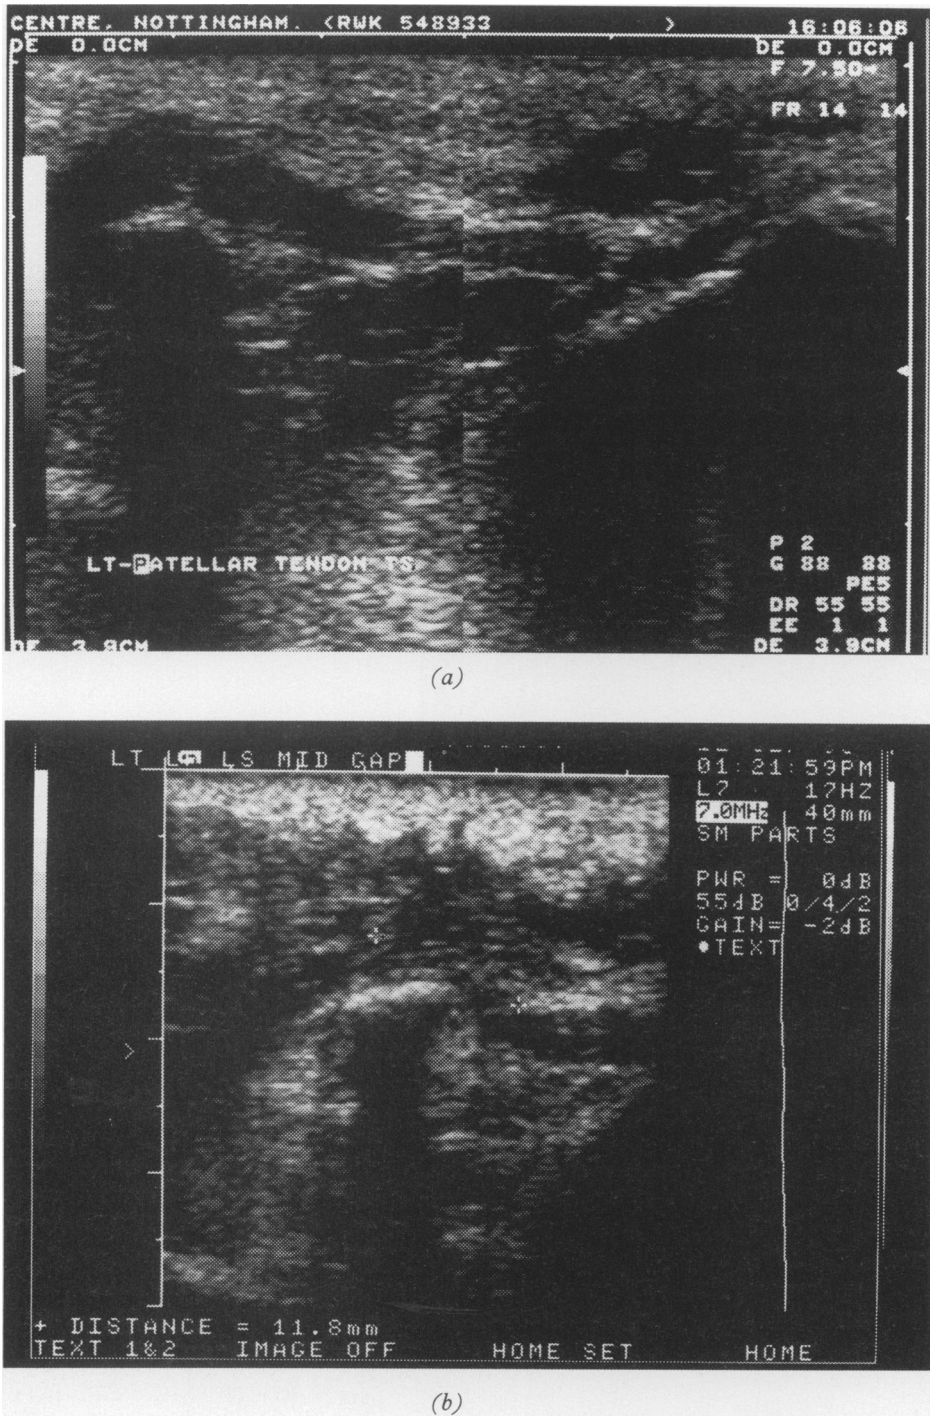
Left patellar tendon. Sagittal section in March 1996 shows inhomogeneous tendon structure with a small partial thickness tear distally (a). On re-representation, ultrasound showed complete loss of tendon continuity with separation of the free edges (cross-hairs) (b).
